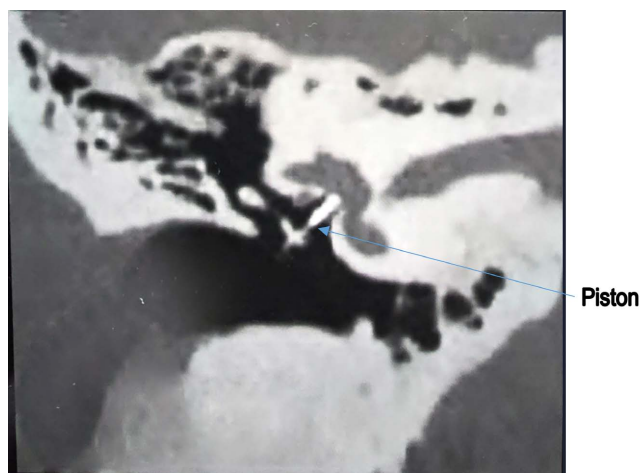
Postoperative frontal CT scan: piston in place.
